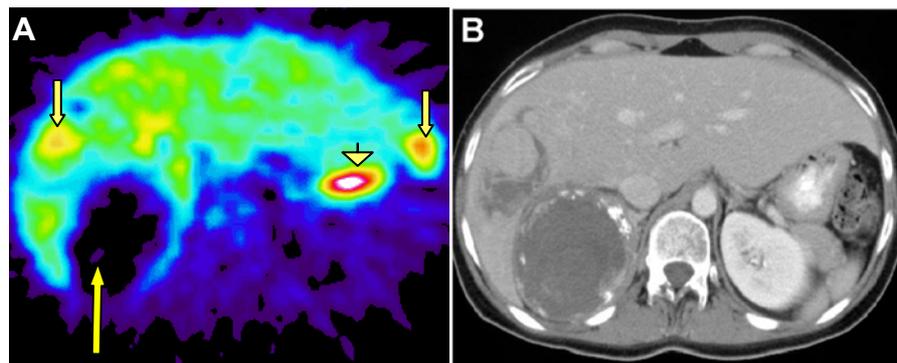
(A) ^{11}C -metomidate PET image; a patient with a right-sided necrotic metomidate-negative primary tumor (*long arrow*), liver metastases (*short arrows*) and a high radioactivity concentration in gastric juice (*arrowhead*). (B) The corresponding CT image; a rim of calcifications surrounds the low attenuation adrenal tumor. Liver metastases are seen as areas of low attenuation.
